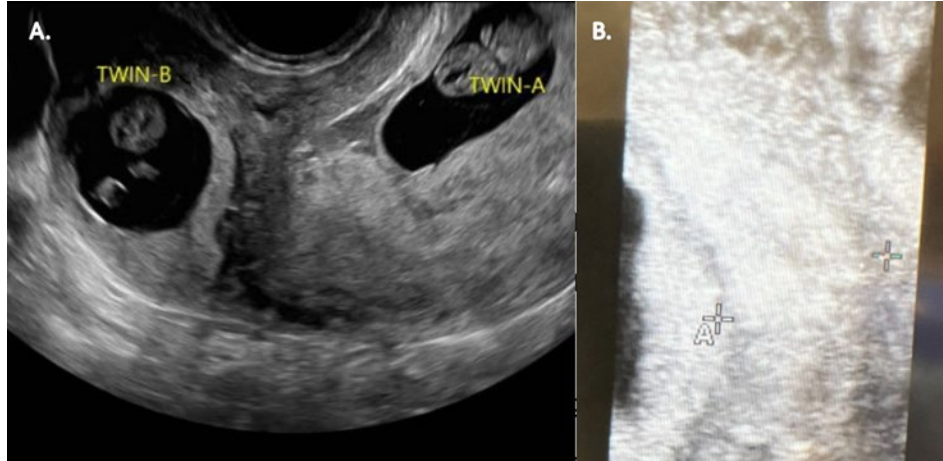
A. Pre-operative transvaginal sonographic image depicting gestational sacs of Twin A (intrauterine) and Twin B (ectopic). B. Intra-operative sonographic image depicting 15 mm between Twin A (intrauterine, left side of image) and Twin B (ectopic).
